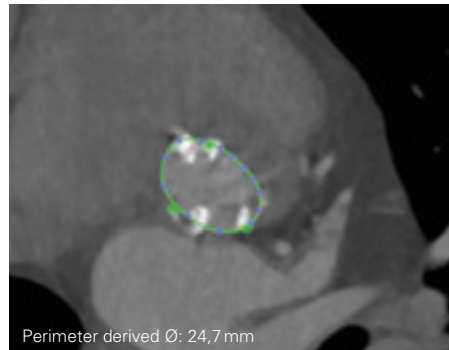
Measurement of the aortic annulus with the CT scan
